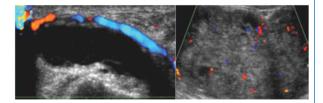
(A, B): (A)Longitudinal US image with Color Doppler showing a well definedanechoiccystic lesion and surrounding the radial artery.(B)Longitudinal US image Nerve sheath tumour- Neurofibroma. showing a lobulated heterogenous soft tissue mass lesion with few areas of cystic degeneration.
